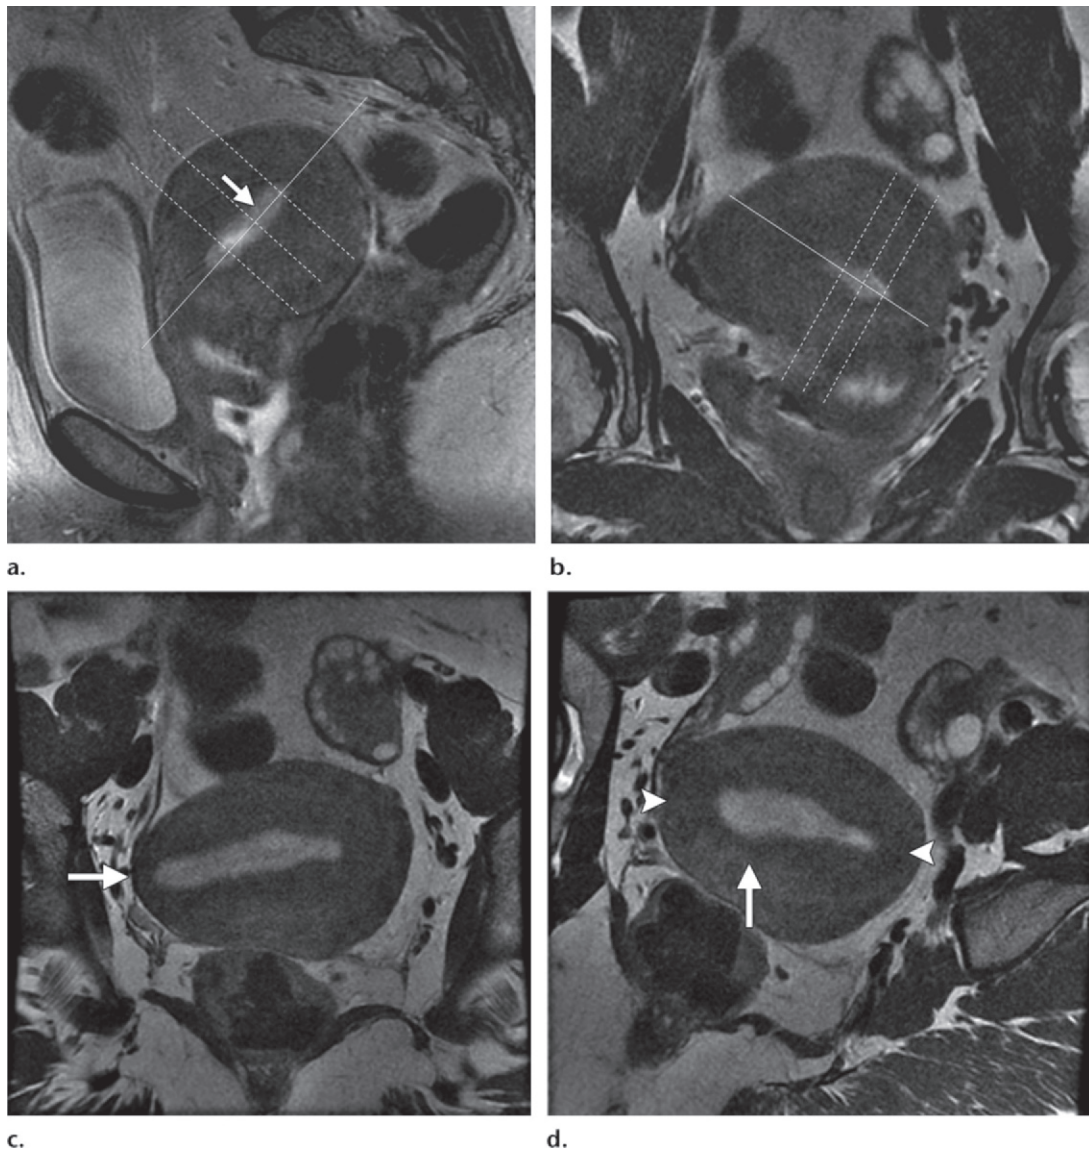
Double oblique technique in a patient with endometrial cancer. (a) High-resolution sagittal T2-weighted FRFSE MR image shows the correct plane for prescribing the orthogonal axial images perpendicular to the endometrial cavity in patients with endometrial carcinoma. Solid line and arrow = long axis of the uterus, dashed lines = plane of acquisition for routine axial oblique sections. (b) Coronal high-resolution FRFSE T2-weighted MR image shows that the body of the uterus is deviated to the right. The second oblique plane is prescribed perpendicular to the axis of the uterus in the coronal plane. The axis of the endometrial cavity in the coronal plane (solid line) and the acquisition plane of the oblique axial images (dashed lines) are seen. The combination of both acquisitions prescribed along the long axis of the uterus in the sagittal and coronal planes forms the double oblique axial image. (c) Axial oblique high-resolution T2-weighted FRFSE MR image shows apparent thinning of the right myometrium (arrow), which may be mistaken for myometrial invasion. (d) Double oblique high-resolution T2-weighted FRFSE MR image prescribed with both the sagittal and coronal planes is more appropriately angled along the true axis of the uterus and shows the thickness of the myometrium to be symmetric (arrowheads). Subtle superficial invasion of the inner myometrium is seen along the anterior wall (arrow). High-resolution double oblique images are particularly useful when lateral deviation of the uterus is seen in the coronal plane and minimize problems with volume averaging that result from the position of the uterus within the pelvis, which may lead to erroneous interpretations of myometrial invasion.
